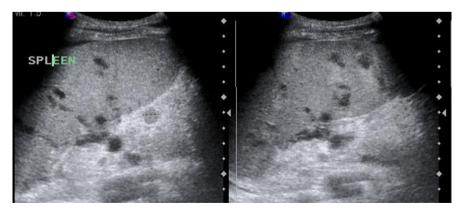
Ultrasound examination of the abdomen shows multiple hypo-echoic lesions in the spleen suggestive of multiple splenic abscesses.
